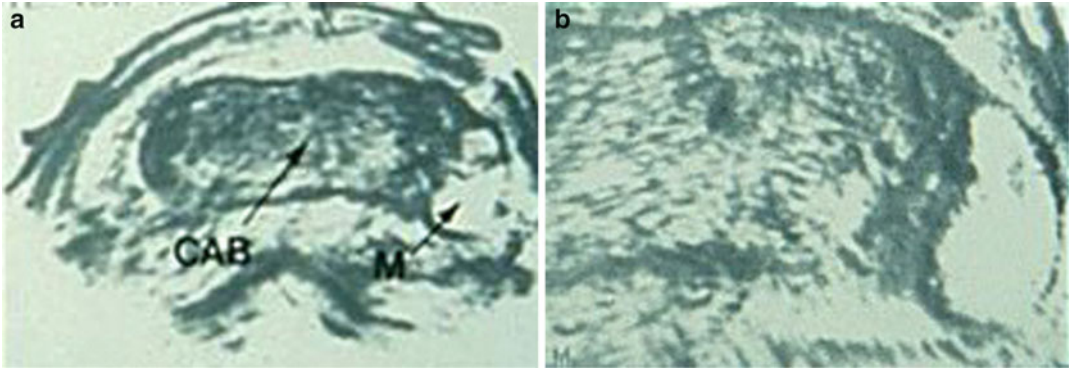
Prenatal ultrasound (a) detected the above conjoined twins with a shared liver (CAB) and separate hearts, stomach, pelvis, and extremities. One fetus was noted to
